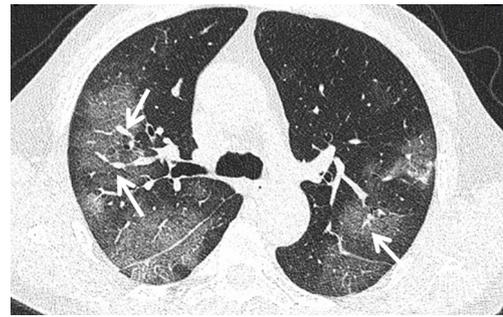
A 52-year-old man with COVID-19. High-resolution CT image shows ground glass opacities with vascular enhancement (arrows).
